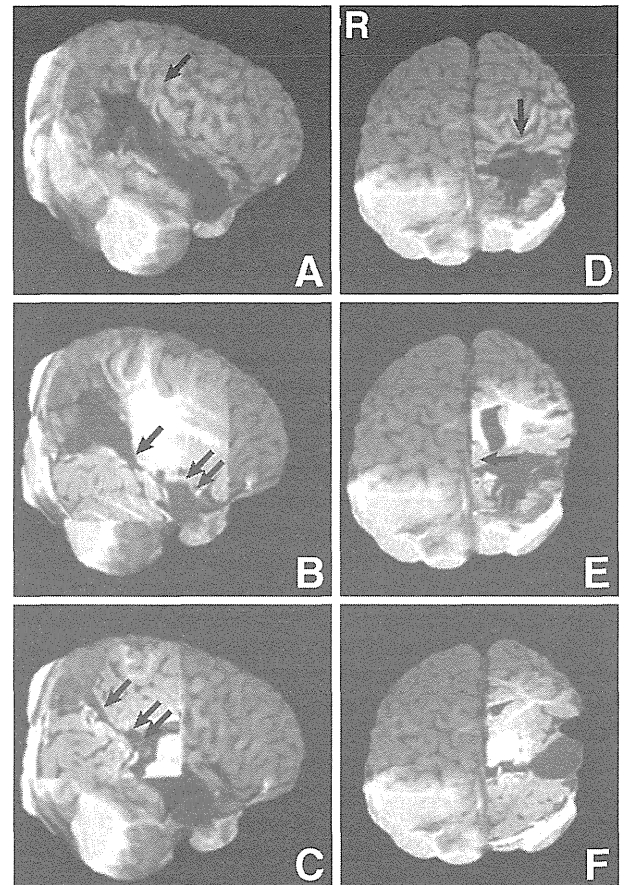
Postoperative three-dimensional surface rendering magnetic resonance images in Case 1. A–C: Lateral view; D–F: axial view; B, C, E, F: cut-out images of the brain (right upper quadrant). A: Surface rendering image showing the periinsular window. The temporal pole, the temporal opercular cortex, and the parietal opercular cortex were resected. The arrow indicates the central sulcus. B: Cut-out image demonstrating mesial temporal resection and posterior hippocampotomy. The arrow indicates the site posterior hippocampotomy was performed. The paired arrow shows resection of the amygdala and the anterior hippocampus. C: Cut-out image demonstrating intraventricular posterior callosotomy and interparietal disconnection. The arrow indicates the site interparietal disconnection was performed. The paired arrow shows posterior callosotomy. D: Surface rendering image showing the interparietal disconnection. The arrow indicates the central sulcus. E: Cut-out image demonstrating intraventricular posterior callosotomy. The arrow indicates the site posterior callosotomy was performed. F: Cut-out image demonstrating mesial temporal resection and posterior hippocampotomy.
